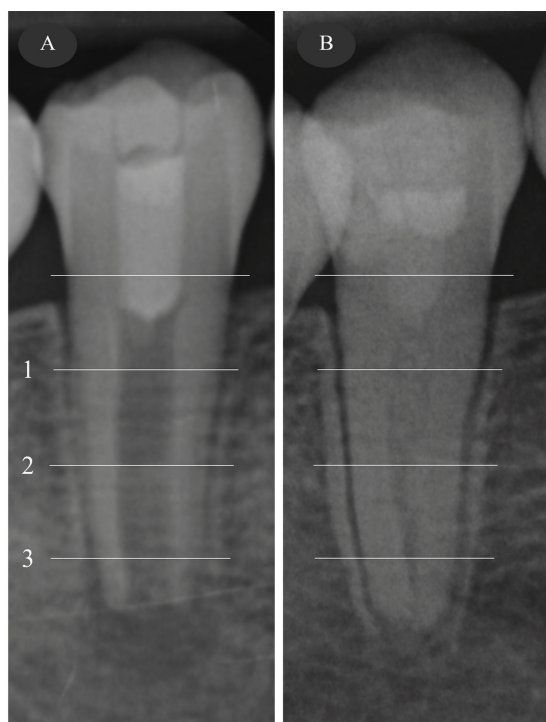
Images showed the three horizontal reference lines for the root and canal width measurements using ImageJ software: (A) a radiograph post-induced bleeding and (B) a 22-month follow-up radiograph. (1=coronal, 2=middle, and 3=apical)
